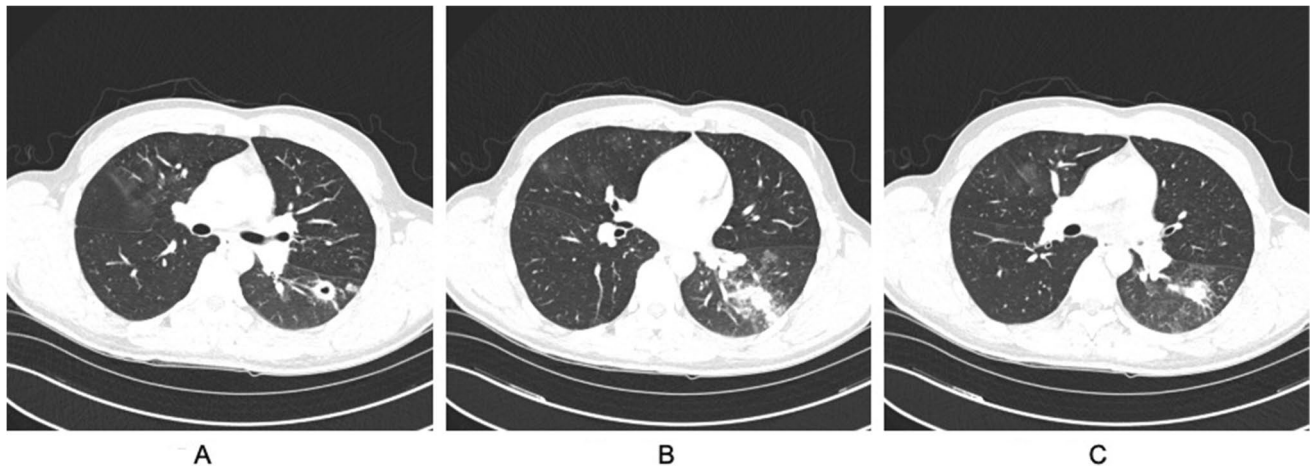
CT chest, non-contrast. Dominant 1.9 cm cavitary nodule (panel A) in the left lower lobe with a nodular consolidation located immediately inferior (panels B & C), consistent with history of coccidioidomycosis
